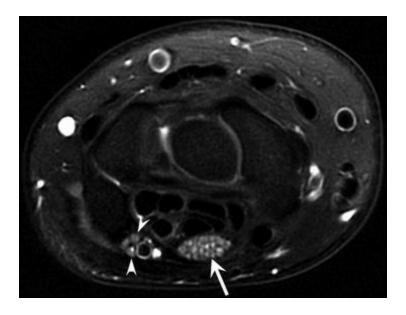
Axial fat-suppressed T2-weighted MRI of the median nerve (*arrow*) and ulnar nerve (*arrowheads*). Peripheral nerves appear isointense to mildly hyperintense as compared with normal muscle. Nerve fascicles, which contain endoneural fluid, may have slightly higher signal intensity than the surrounding connective tissue
